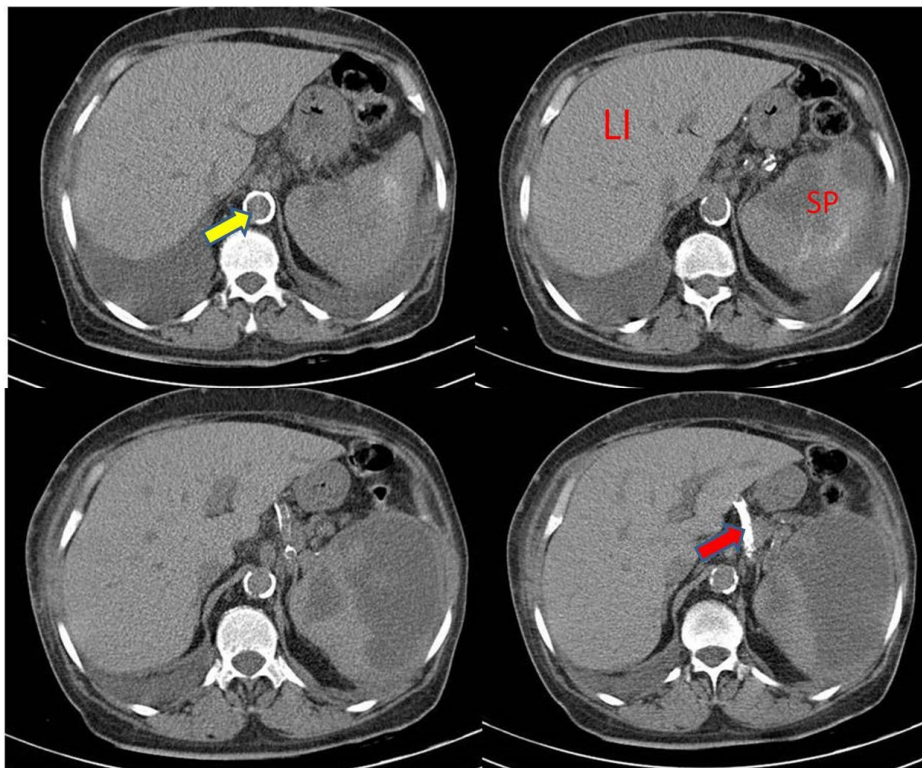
Axial non-contrast CT scan (16-slice) of the abdominal region revealing atherosclerosis with splenic infarction. Yellow arrow: aorta; red arrow: splenic artery; S: spleen; LI: liver.
